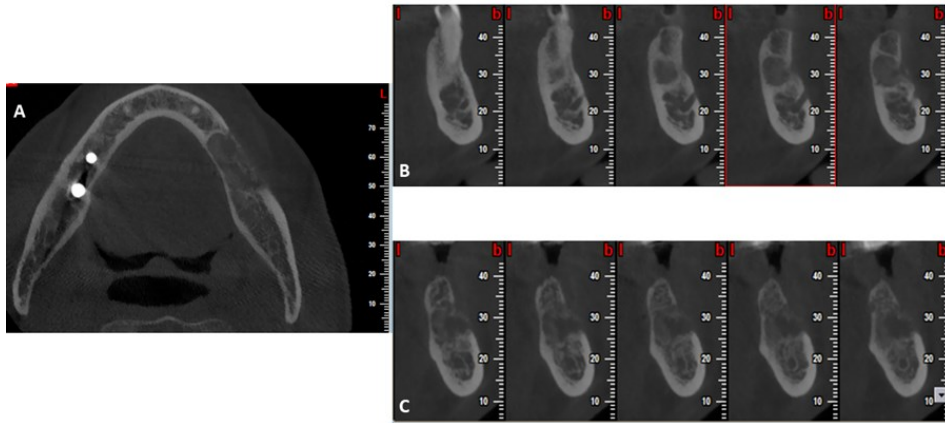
Post-operative cone beam computed tomography images: (A) Axial view of the mandible showing healing of the site, (B) cross sectional view showing the cavity filled partially with bone.
